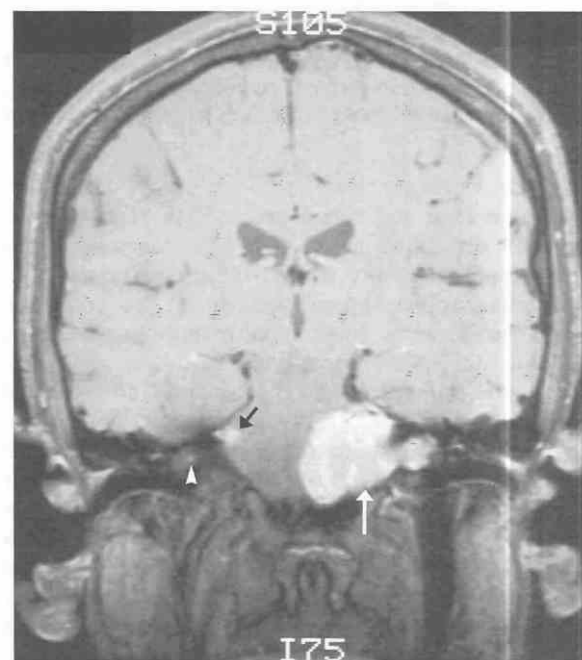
Bilateral vestibular schwannomas and right trigeminal schwannoma in a patient with neurofibromatosis type 2. Coronal postgadolinium T1-weighted MR image demonstrates three intensely contrast enhancing lesions in the posterior cranial fossa. The large left sided lobulated vestibular schwannoma fills the left cerebellopontine angle cistern (white arrow), compresses, indents and displaces the left lateral margin of the pons inward, and extends laterally into the widened left internal auditory canal. A tiny punctate focus of contrast enhancement in the right petrous temporal region (white arrowhead) represents a small intracanalicular vestibular schwannoma. A third focus of contrast enhancement abuts and indents the right lateral margin of the pons (black arrow); this is a trigeminal (fifth cranial nerve) schwannoma.
